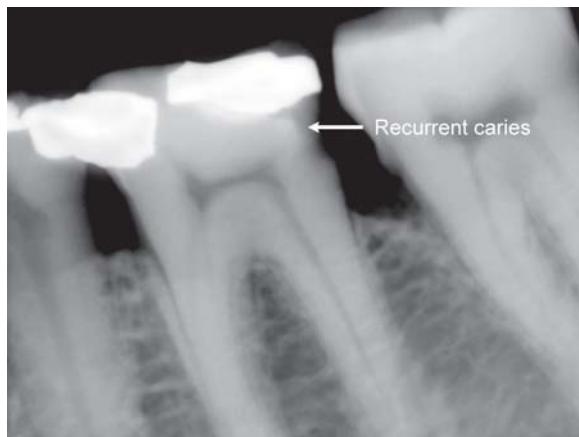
Radiograph showing recurrent caries
